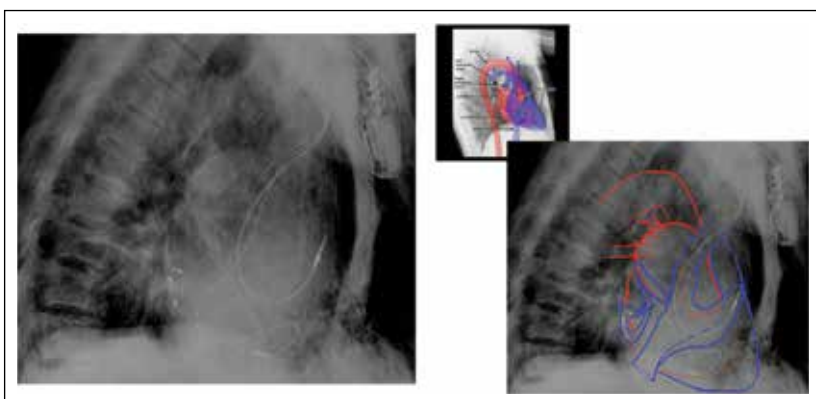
Lateral chest radiograph showing different lead positions (RA, RV, LV leads) in relation to the cardiac chambers. Annotated image showing the same.
